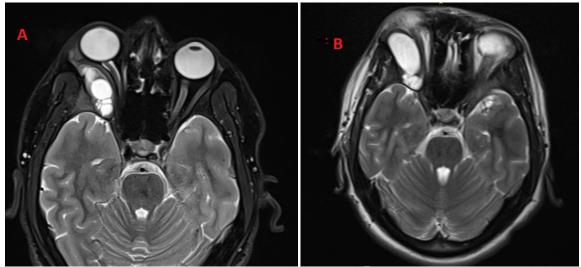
A comparison between two Magnetic Resonance Imaging (MRI) scans, taken approximately 10 months apart, reveals a significant and rapid growth (300%) of the hydatid cyst in the right orbit and surrounding craniofacial structures. the first presentation (A) to maxillofacial team in December 2023, and the later presentation (B) to the oculoplastic team in October 2024.
